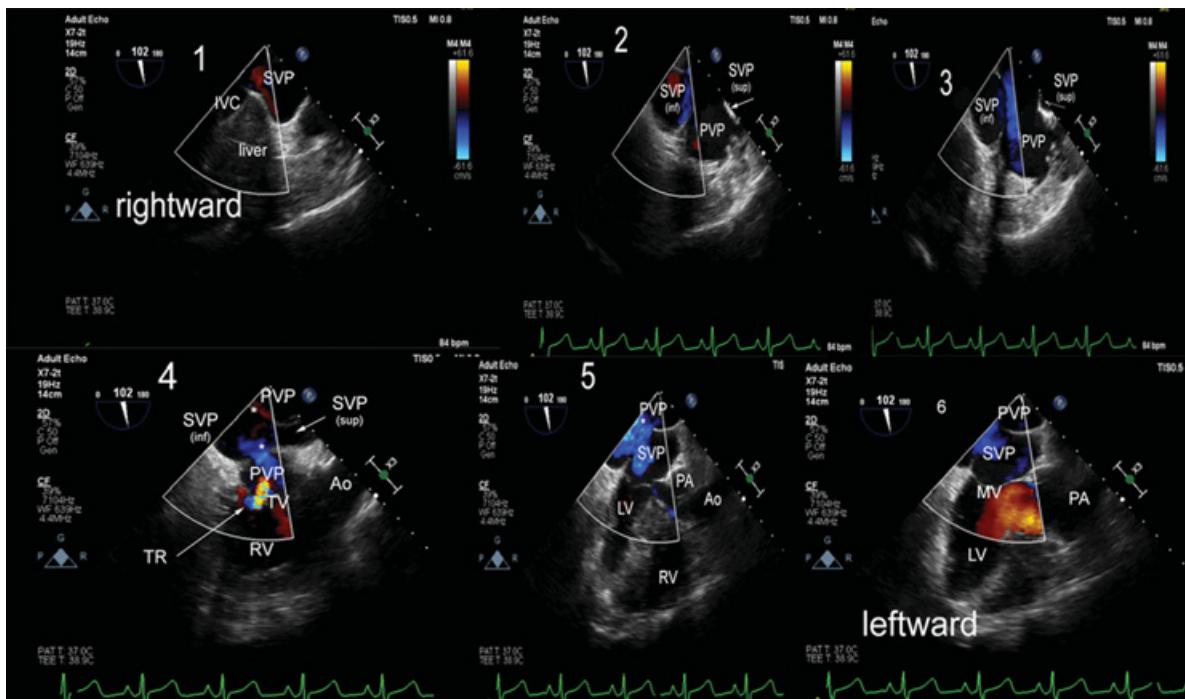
TEE color flow Doppler 102° rotation (orthogonal) sweep from the right to the left (counterclockwise). The right of the screen is superior, the left inferior, the bottom anterior, and the top posterior. (1) The IVC is located and allows identification of the inferior portions of the SVP. (2–3) The probe is withdrawn to the ME level and turned leftward. Both limbs of the SVP are seen on either side of the PVP. (4) The first ventricle visualized during the rotation is the RV. The RV, TV, and Ao are seen. Both limbs of the SVP are seen to merge. The PVP is seen posterior and closest to the TV valve. Mild to moderate TR is seen. Two baffle leaks are seen in this image (asterisks). (5) With further leftward rotation both ventricles are seen. The pathway closest to the MV is the SVP. The more posterior baffle leak is now seen between the PVP and SVP (asterisk). Note, the shunt here is left-to-right, which is the predominant overall direction of the shunt in this patient. (6) With the probe rotated all the way to the left, the LV and PA are seen, and no further shunt is visible. Ao, aorta; Inf, inferior; IVC, inferior vena cava; ME, mid-esophageal; PA, pulmonary artery; PVP, pulmonary venous pathway; RV, right ventricle; Sup, superior; SVP, superior venous pathway; TR, tricuspid regurgitation; TV, tricuspid valve.
